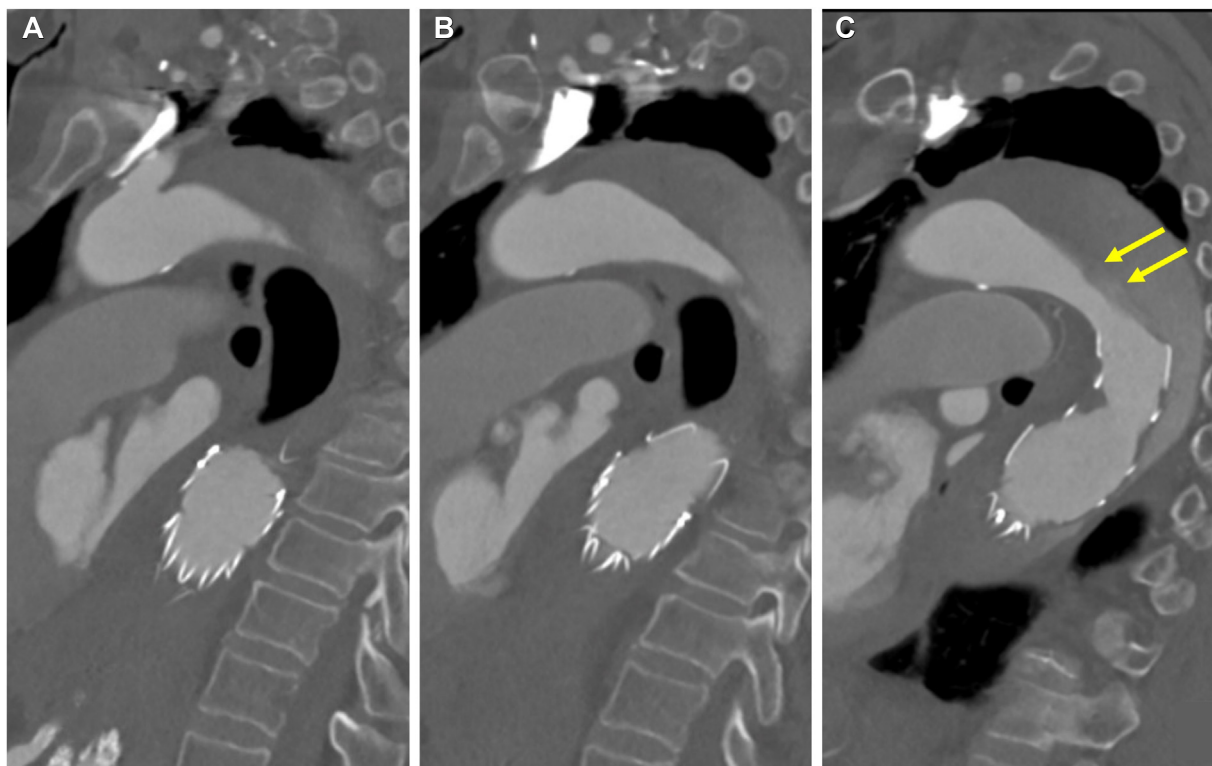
Emergent computed tomography angiogram showing a new type B₃₋₅ aortic dissection extending from the left subclavian artery into the proximal stent graft with acute enlargement of the involved descending thoracic aorta. A, Most proximal extent. B, Most distal extent. C, Location of the septal fenestration (arrows), which was confirmed by intravascular ultrasound (IVUS).
